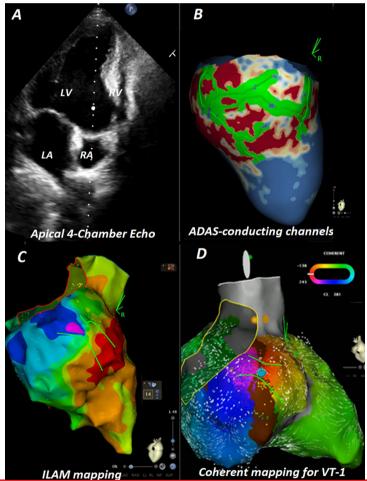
(A) Echocardiography shows inferoseptal aneurysm. (B) CMR with ADAS software shows the endocardial channel (green lines). (C) ILAM during the sinus rhythm shows the isochronal crowding/DZ as perfectly compatible with ADASguided channel (C), and coherent mapping (D). CMR, cardiac magnetic resonance; DZ, deceleration zone; LAM, late activation map.
